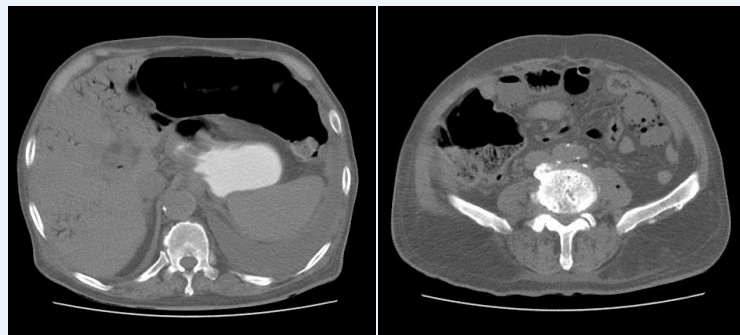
Axial abdominal CT scan of patients.
